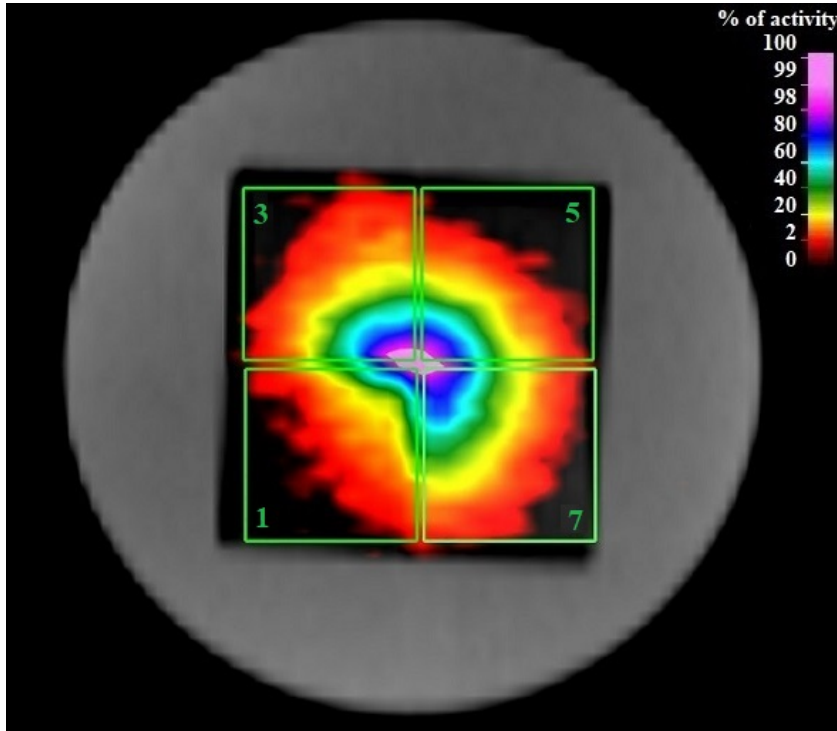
Four VOIs in the activity distribution measured in the PET overlaid with the CT. Numbers indicate the number of sheets in each quadrant.
